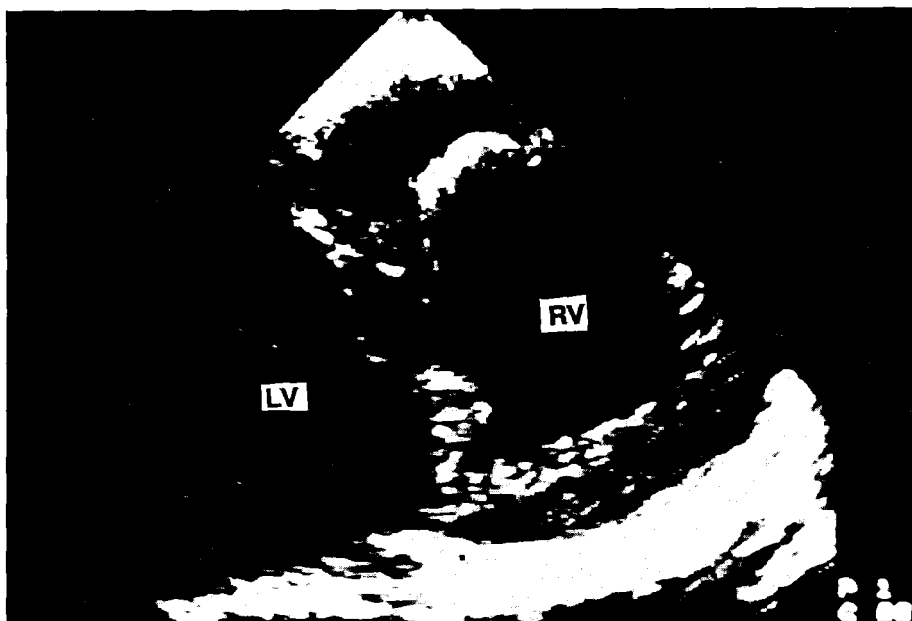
Transesophageal view for definition of chordal attachments in a patient with congenitally corrected transposition and associated inlet ventricular septal defect. Chordae of either AV valve are demonstrated to insert into the crest of the ventricular septum (arrows), however, there is no chordal straddling. The patient subsequently underwent biventricular repair.
